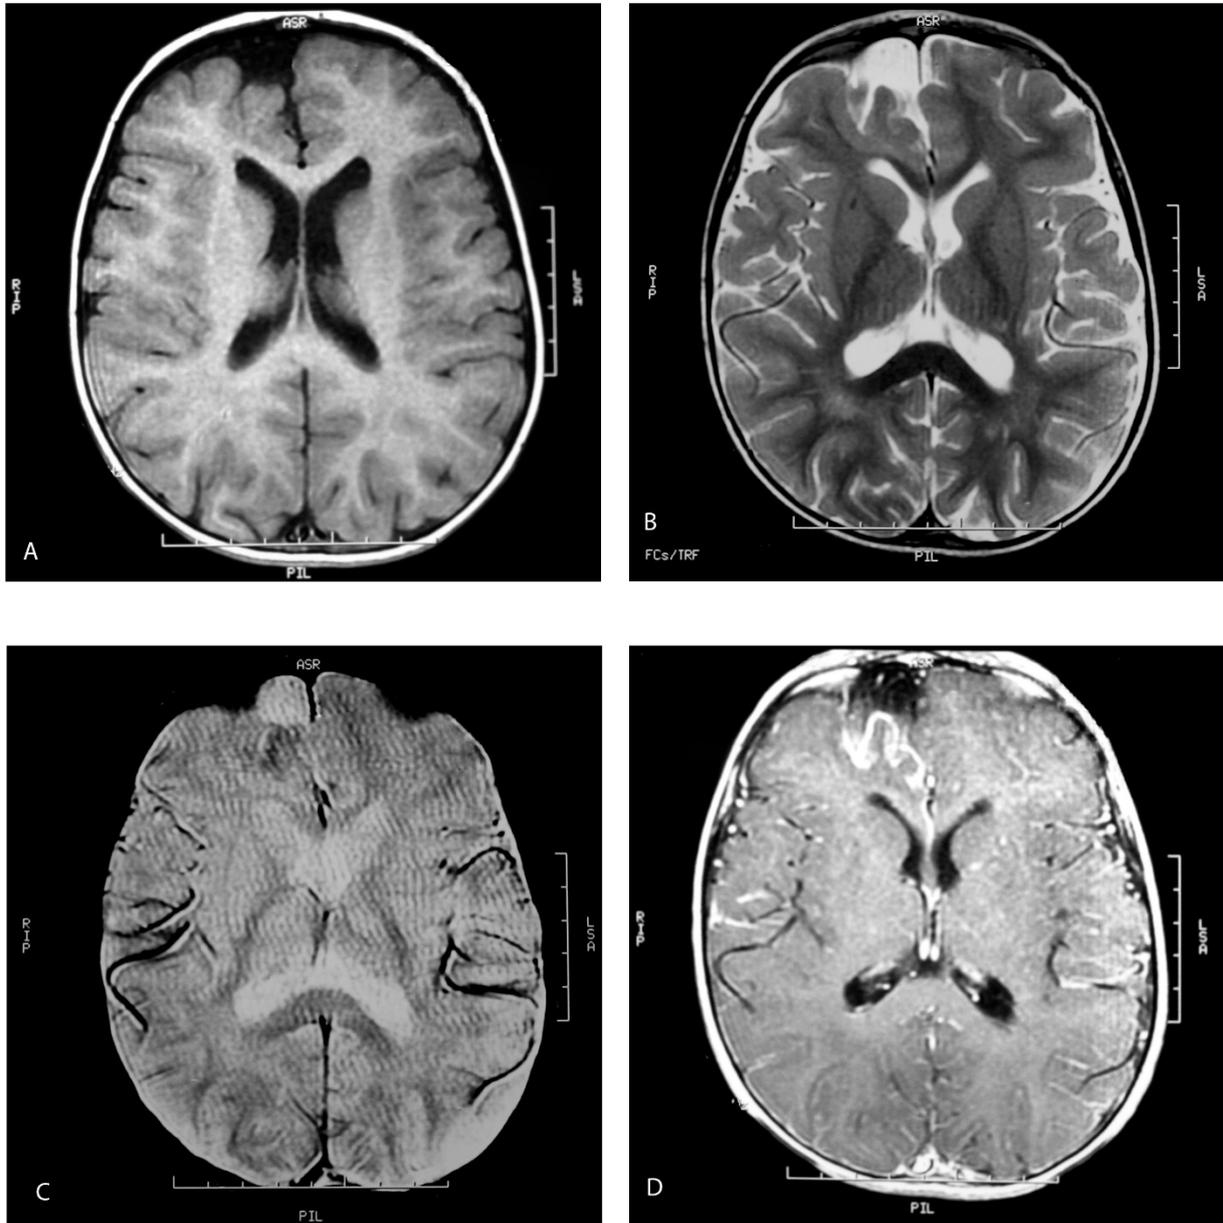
Axial T1 (a) and T2 (b) Weighted-images showing focal gyral atrophy at the right anterior frontal lobe. Axial Gradient Echo image (c) demonstrating subcortical blooming artefact reflecting calcification seen on CT. Prominent focal leptomenigeal enhancement over the right anterior frontal lobe is seen on axial T1W post contrast image (d)
